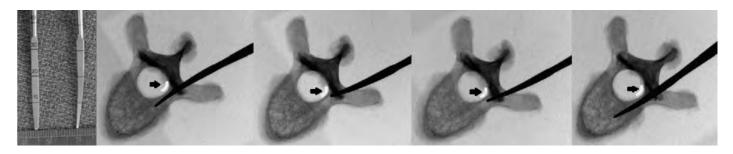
Axial radiographs of thoracic vertebrae, using an angled pedicle probe with tapered 2-mm tip, with tip pointed lateral, then re-inserted with tip pointed medial to palpate and scrape laterally along the ventral lamina (arrow) to fall into the pedicle.
